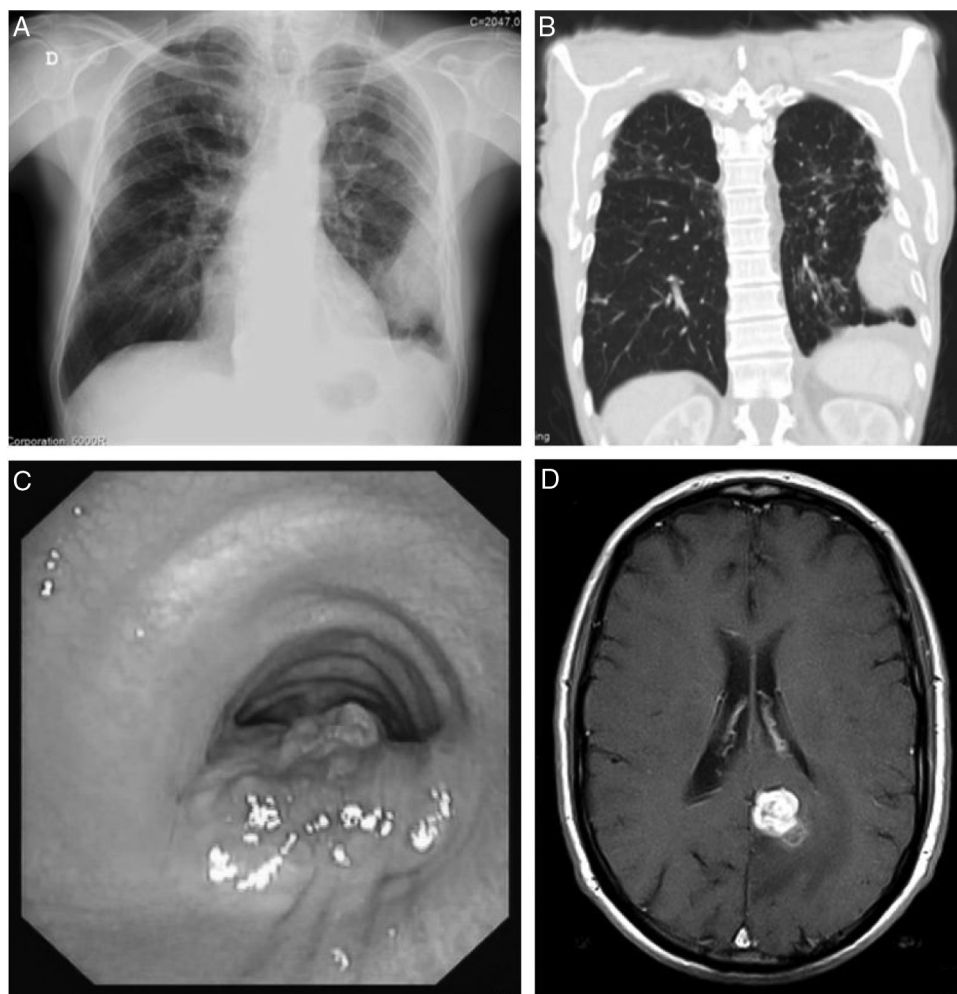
Sites of *Rhodococcus equi* infection. (A) Lung as a consolidation in the left pulmonary field on posteroanterior X-ray; (B) lung as a mass on the periphery of the left upper lobe on chest computed tomography; (C) trachea as a protruding lesion leading to obstruction of about 50% of the lumen; (D) brain as an abscess in the left parasagittal occipitoparietal location on magnetic resonance.
